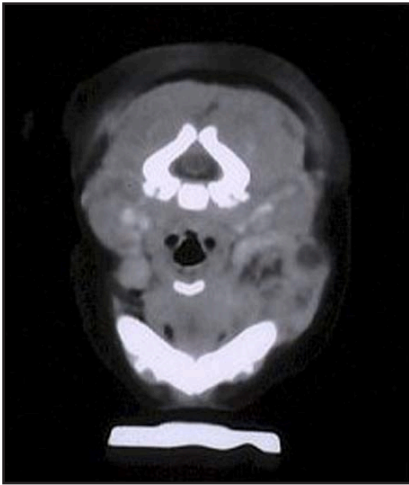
CT scan of area of the abnormality
